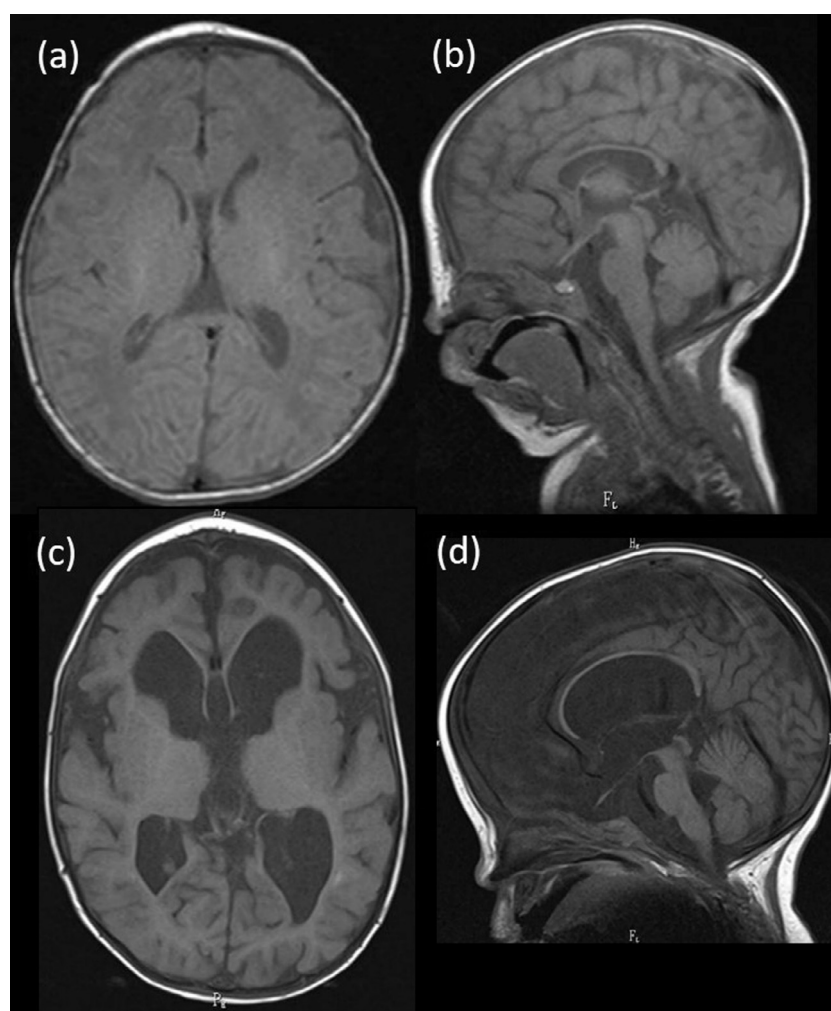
Cranial MRI findings at one month of age (a, b) and two years of age (c, d). Both axial (a) and sagittal (b) T1-weighted images show a normal brain morphology. An axial T1-weighted image shows ventriculomegaly with diminished white matter areas (c). A sagittal T1-weighted image reveals hypoplasia of the corpus callosum, indicating white matter volume loss (d).
